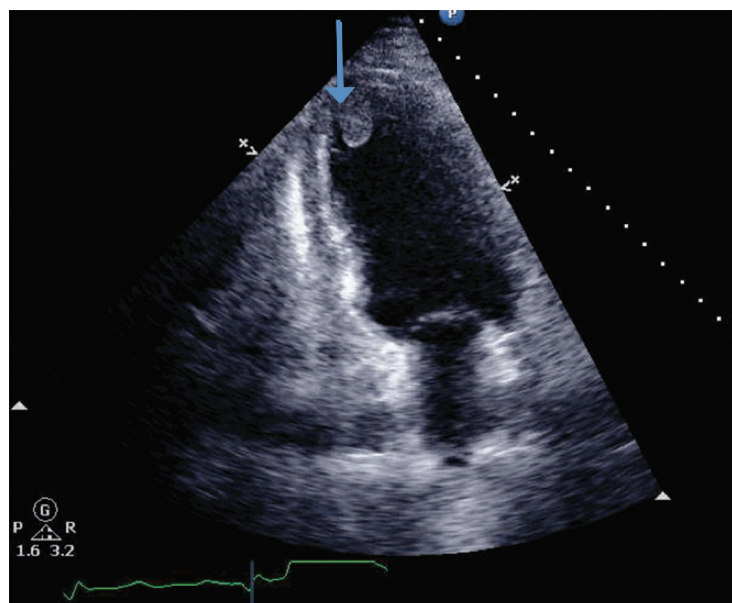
Transthoracic echocardiography, apical four-chamber view, shows thrombus in the left ventricular apical cavity. The blue arrow points to the well-demarcated thrombus adhering to the endocardium.
